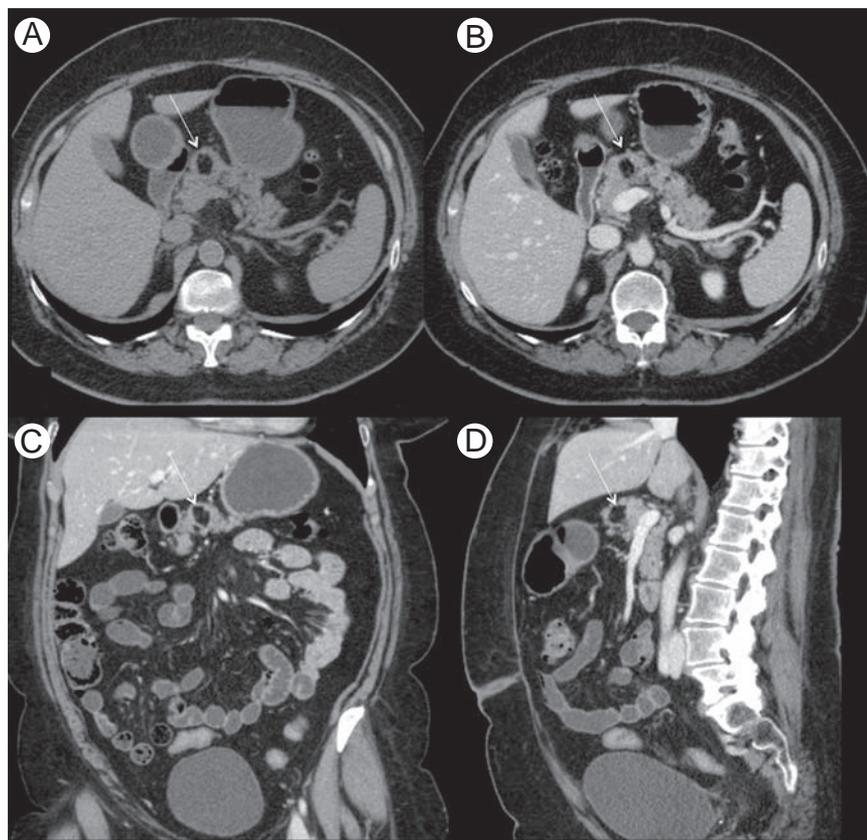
Incidental intrapancreatic small circumscribed lipoma in the head of the pancreas in a 50-year-old woman, stable for 3 years. Axial unenhanced (A) and axial (B), coronal (C), and sagittal (D) contrast-enhanced CT images shows fat attenuation of the lesion (arrows), without enhancement.
